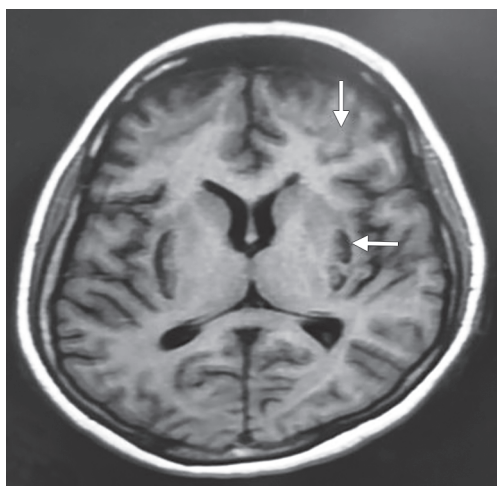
T1-weighted (T1W) MRI showing hyperintensities suggestive of toxic encephalopathy (white arrows)
